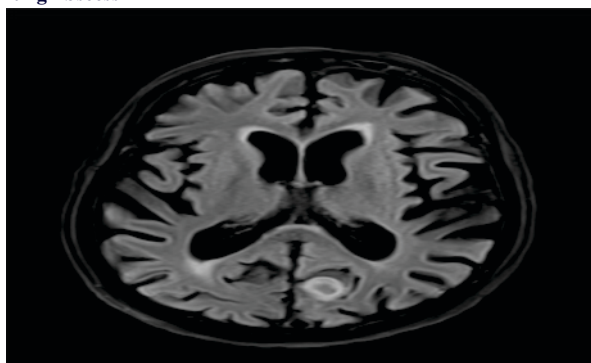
MRI Brain Shows Well Defined Altered Signal Intensity Lesion With Perilesional Edema In Left Parasagittal Occipital Lobe — Brain Abscess
